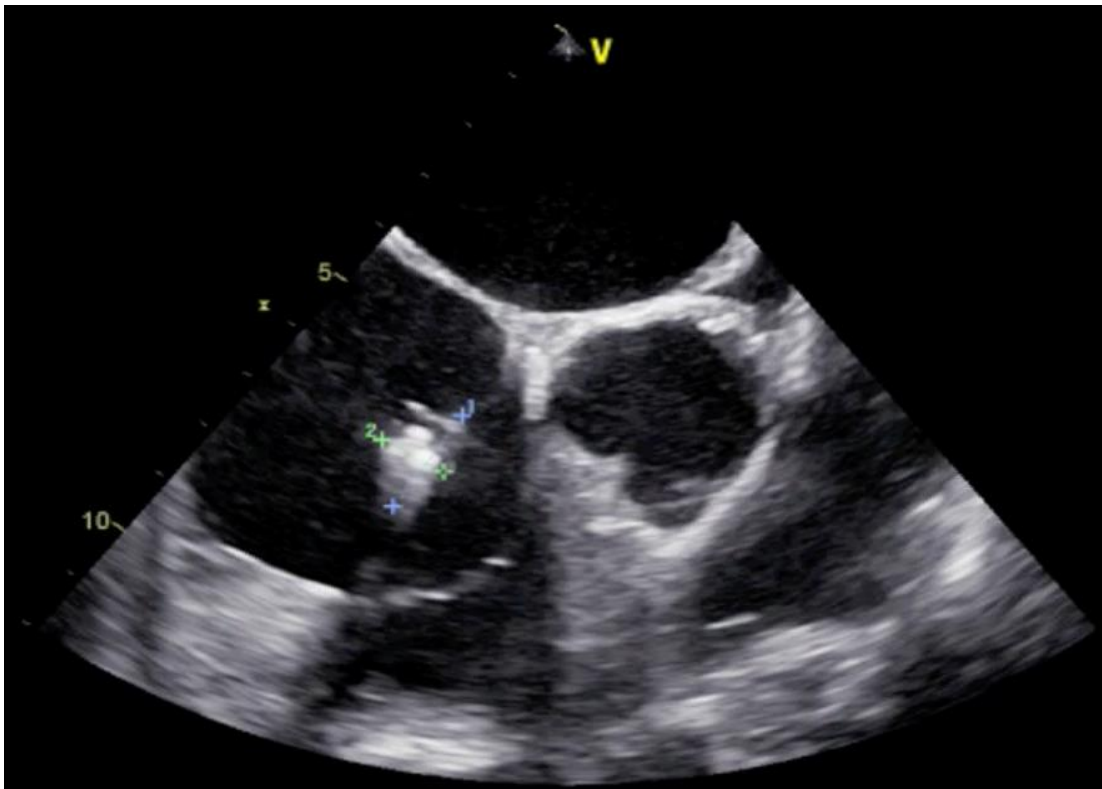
Multiple masses around the lead were observed during a transesophageal echocardiography study.
